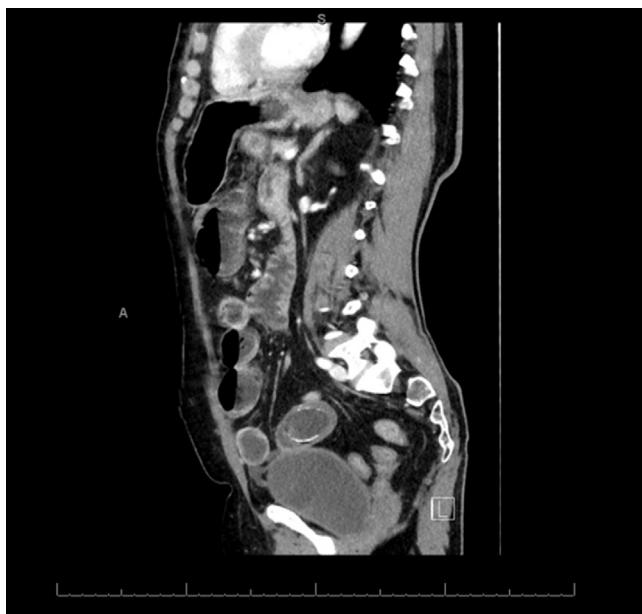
CT scan shows gallstone in the ileus.
